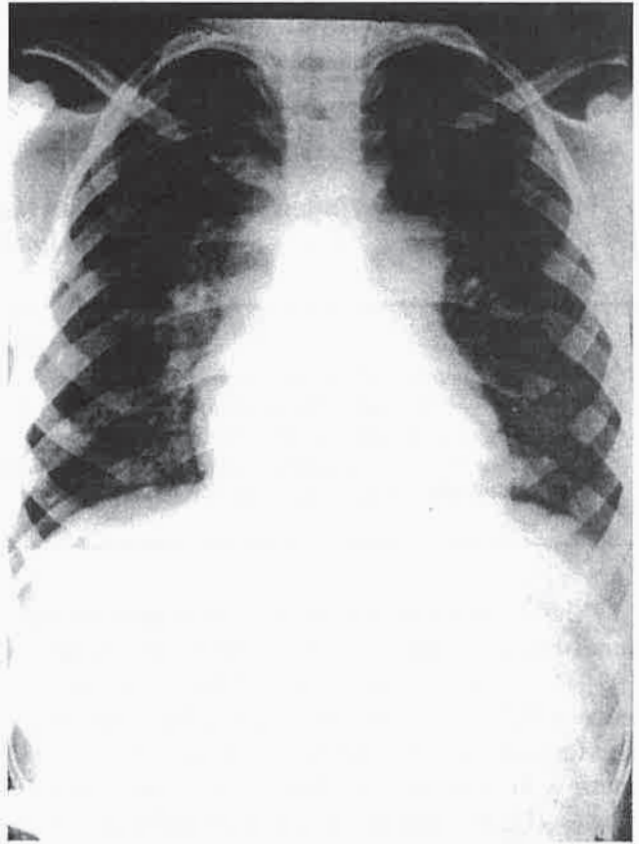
Chest roentgenogram from patient when pulmonary hypertension was diagnosed showing increased prominence of the main pulmonary artery segment.
